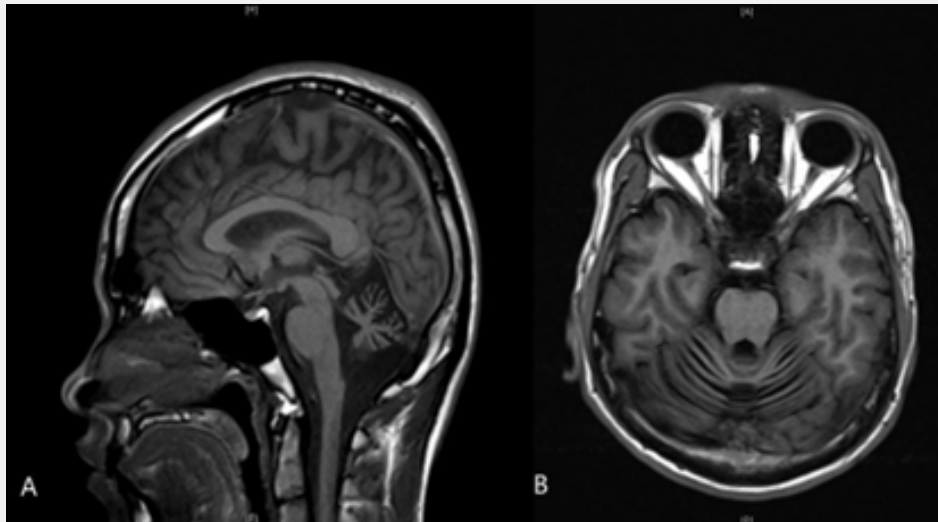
MRI scans showed cerebellar atrophy. Arrows indicate lesion site.
